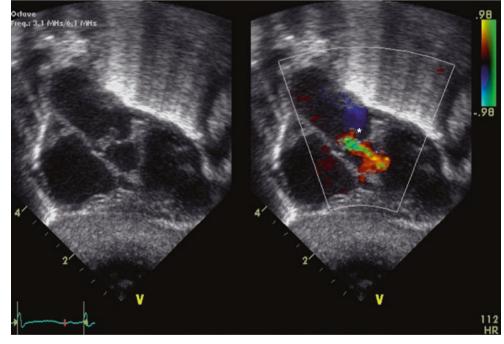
Echocardiography showing a truncus arteriosus with a moderate regurgitation of the truncal valve (*)
